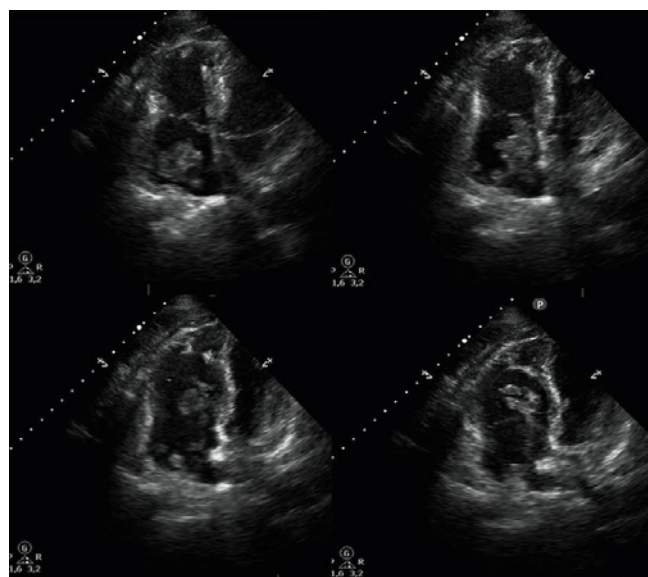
Transthoracic echocardiogram images revealing the presence of a large mobile thrombus in the right atrium.
